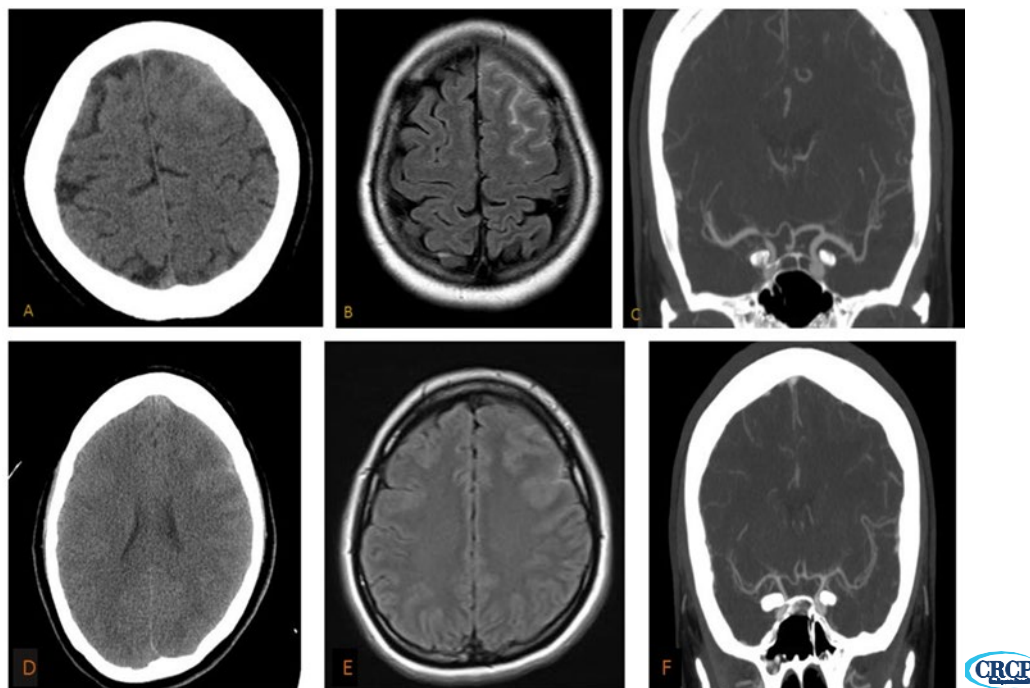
Brain CT, MRI, CTA of case#1. D, E, F) Brain CT, MRI, CTA of case#2
